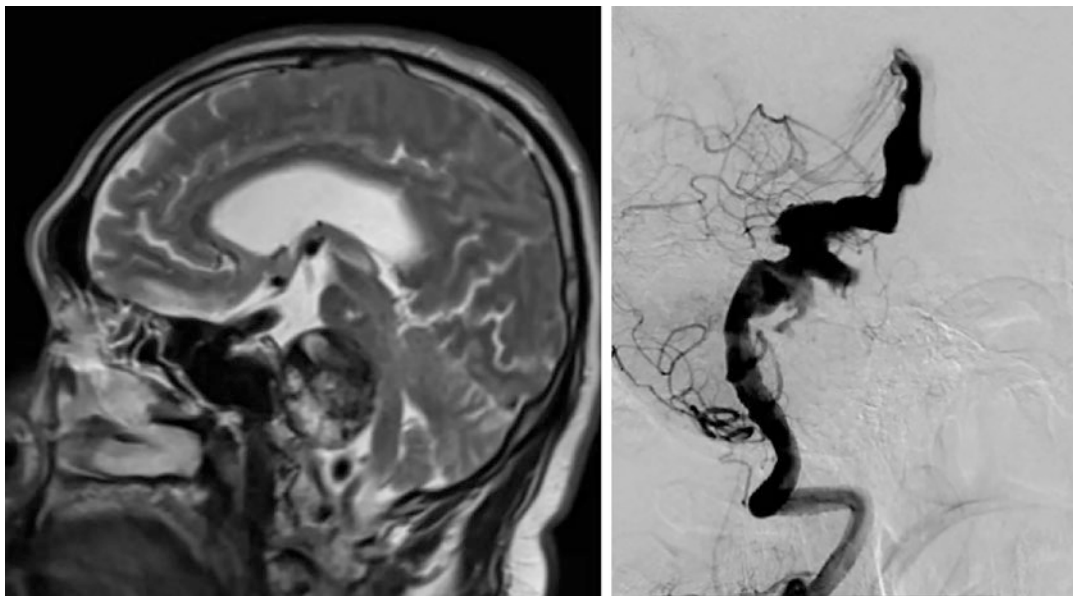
A patient presented with symptoms of mass effect from vertebralbasilar transitional aneurysm. MRI revealed the partially thrombosed and superimposed dilation portion of basilar artery with compression of brain stem
